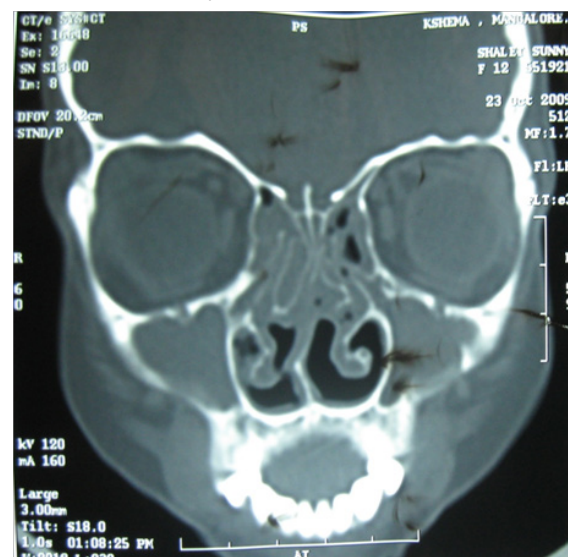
CT scan of a patient with bilateral nasal polyp (before treatment).
